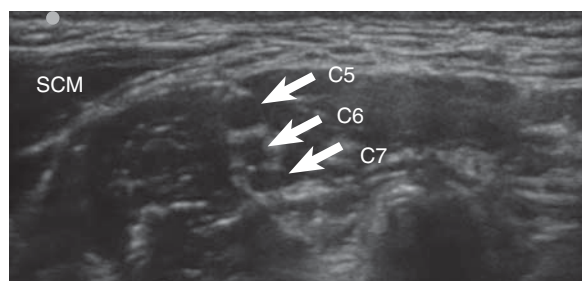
Ultrasound scan of the C₅₋₇ nerve roots at the level used for the interscalene approach. SCM, sternocleidomastoid muscle; C₅, C₆, C₇, cervical nerve roots.
